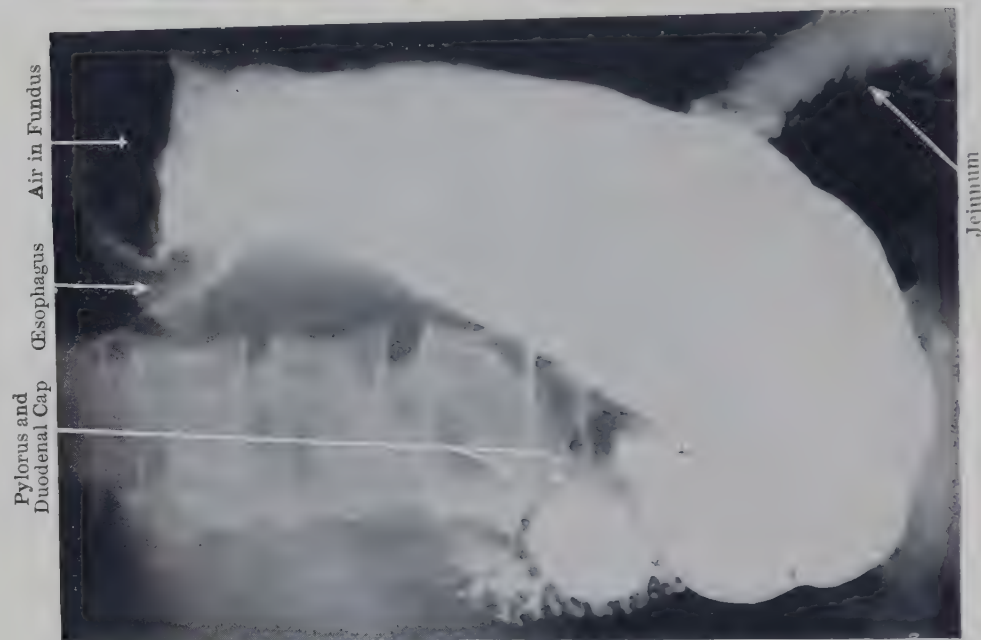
RADIOGRAPH OF THE SAME STOMACH AS IN FIG. 1 AT A LATER STAGE OF EMPTYING, WITH SHALLOWER PERISTALTIC WAVES (x).
